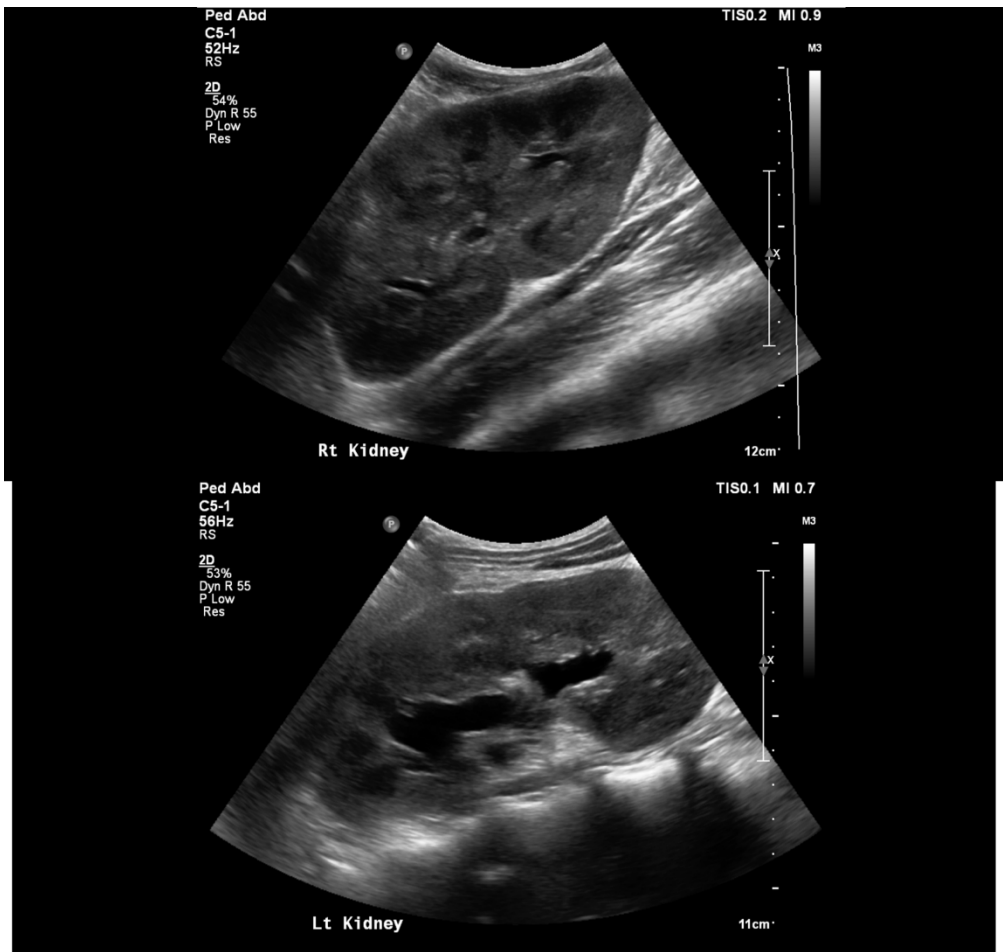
Renal Ultrasound - Right Kidney
